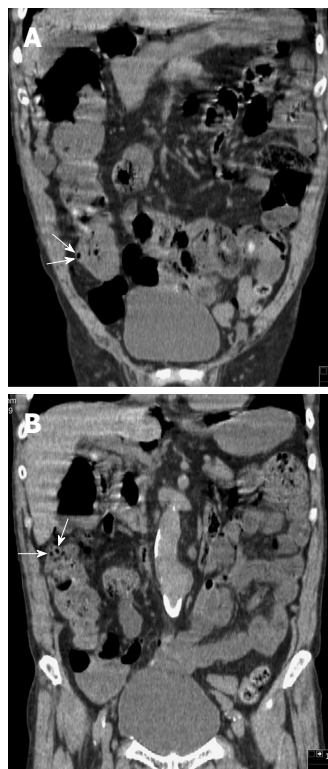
Computed tomography scans in the coronal plane showing sporadic intramural air-filled cysts in the ascending colon.
